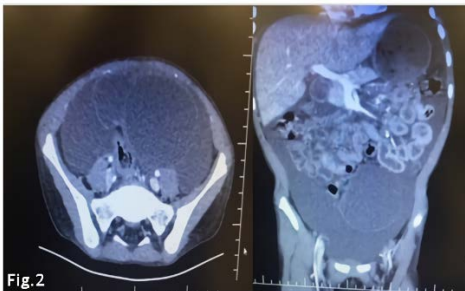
Axial and coronal section computed tomography: Widespread free fluid and two cystic lesions compressing the small intestines superiorly and left laterally, in the abdominopelvic region
